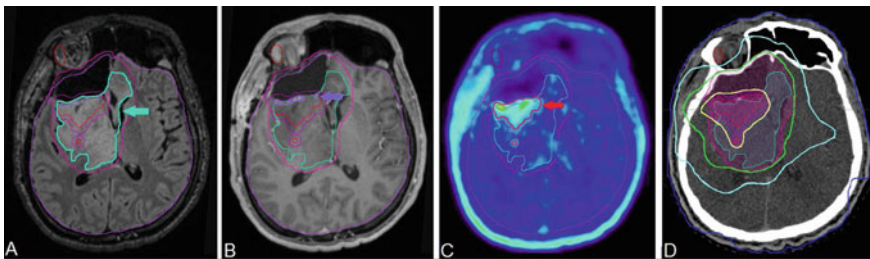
Patient with oligodendroglioma WHO[°]III. After partial resection, imaging studies were performed for individual radiotherapy planning. a MRI-T2-weighted-fluid-attenuated inversion recovery (FLAIR) sequence: Gross tumour volume (GTV) according to FLAIR is highlighted in turquoise (->). b MRI-T1 sequence with gadolinium contrast enhancement (CE): GTV according to CE is highlighted in purple (->). c 18F-(fluoroethyl)-L-tyrosin positron emission tomography sequence (FET-PET): GTV according to FET-PET is highlighted in red (->). It is much larger than GTV-CE, but smaller than GTV-FLAIR, since it does not include edema. d Radiation plan using intensity-modulated radiotherapy (IMRT) with simultaneous integrated boost (SIB) to the GTV-FET; yellow: 95%-isodose (57 Gy), green: 76%-isodose (45.6 Gy), turquoise: 50%-isodose (30 Gy)
